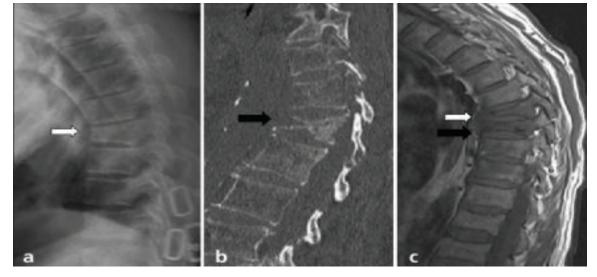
a)* X-ray images of vertebral compression fracture with anterior wedging (white arrow) b) CT (computed tomography) scan of biconcave vertebral compression fracture (black arrow) c) T2 weighted MRI (magnetic resonance images) of wedge vertebral compression fracture (white arrow), and biconcave vertebral compression fracture (black arrow).²⁸
